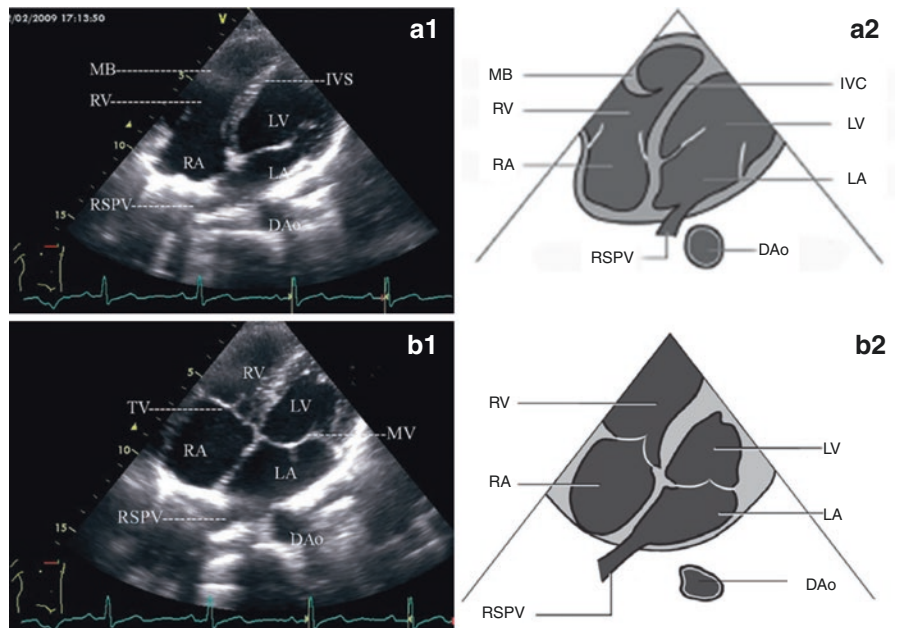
Parasternal four chamber view (a) Diastole (b) Systole MB Moderator band, RV Right ventricle, RA Right atrium, RSPV Right superior pulmonary vein, DAo Descendign aorta, LA left atrium, LV left ventricle, IVC Inferior vena cava (Reprinted with permission from He [61], p. 84)
